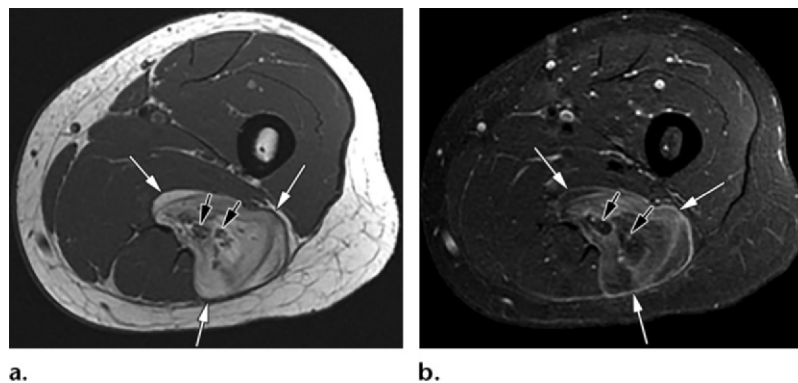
ALT in a 52-year-old woman with a painless left posterior thigh mass. (a) Axial T1-weighted MR image shows a heterogeneous fat-containing mass (white arrows) with thickened internal septa in linear and swirled configurations within the posterior compartment. Note the tibial and common peroneal nerves (black arrows) encased by the mass. (b) Axial postcontrast fat-saturated T1-weighted MR image shows suppression of fat signal intensity and enhancement of the capsule (white arrows) as well as thickened internal septa (black arrows) as well as thickened internal septa. Note the tibial and common peroneal nerves (black arrows) encased by the mass.
